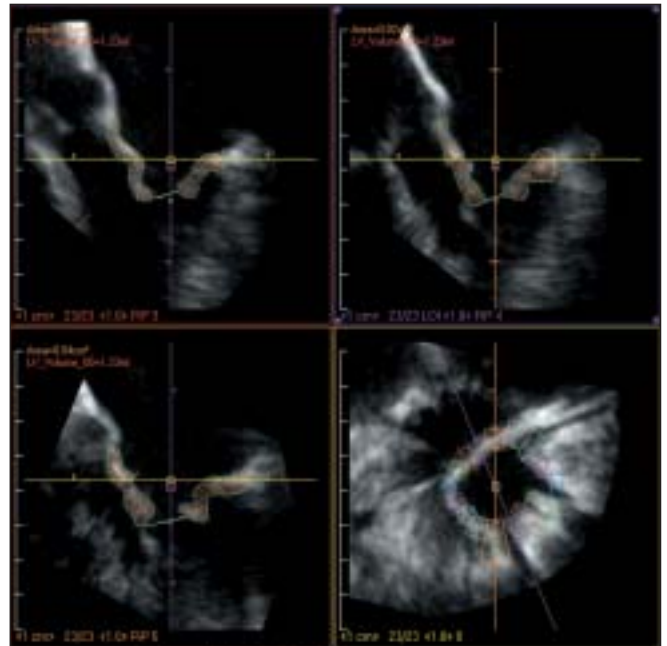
Volume measurement of mitral valve leaflets by anyplane echocardiography. Three long-axis cut planes constructed around centre axis of mitral apparatus (A, B and C). In these views, boundaries of mitral valve subvolumes were traced and their corresponding short-axis views are presented in short-axis cut plane (D). In all, 8 slices were used for volume computation. After the volume of each slice had been calculated, the system summed the corresponding subvolumes and finally calculated the volume of the whole mitral valve. (From: Langerveld J, Valocik G, et al. Additional value of three-dimensional transesophageal echocardiography for patients with mitral valve stenosis undergoing balloon valvuloplasty. *J Am Soc Echocardiogr* 2003;16:841-9.)
